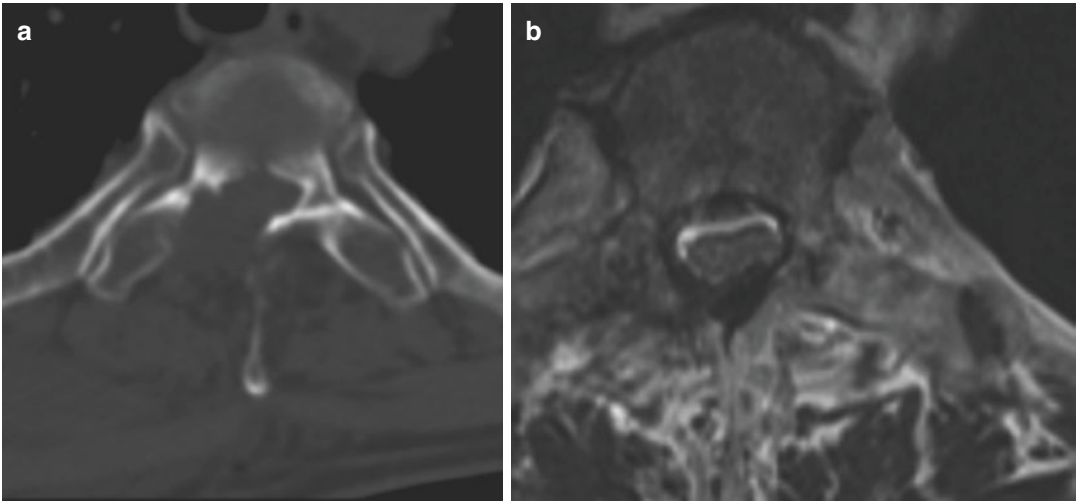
(a) The postoperative CT image showed a surgical corridor to decompress the spinal canal by right hemilaminectomy and partial medial pediclectomy. (b)
